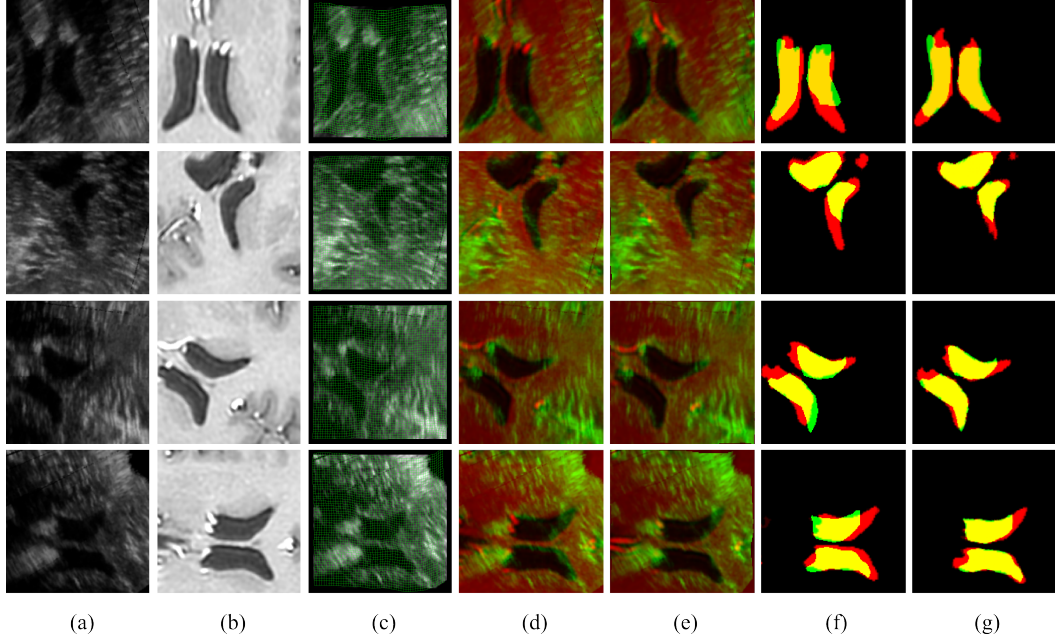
Results for one slice from four of the six brain sequences (each row correspond to a different sequence). (a) Source 2D US image. (b) Slice extracted from the MRI corresponding to the initial position of the plane. (c) Deformed source image overlapped with the estimated deformation field. (d) Blending between initial images (US and corresponding MRI slice). (e) Blending between final images (Deformed US image and estimated MRI slice). (f) Overlapping between initial segmentations. (g) Overlapping between segmentations after registration.
